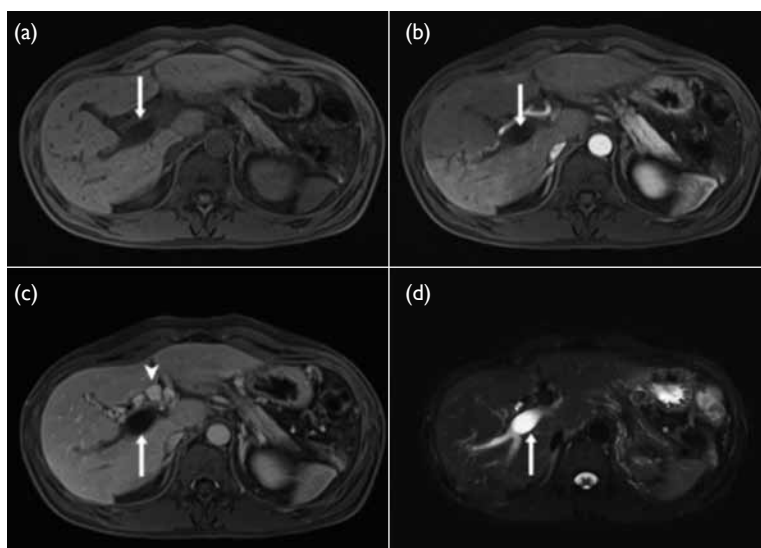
Axial magnetic resonance images: (a) T1-weighted pre-contrast image and (b) T1-weighted post-contrast arterial phase image showing low signal in the main and right portal veins without contrast enhancement (arrows); (c) T1-weighted post-contrast portal venous phase image showing low signal in the main and right portal veins without contrast enhancement (arrow), and with collateral veins at the hepatic hilum (arrowhead) suggesting cavernous transformation; and (d) T2-weighted image showing high signal intensity within the right and main portal veins (arrow)
